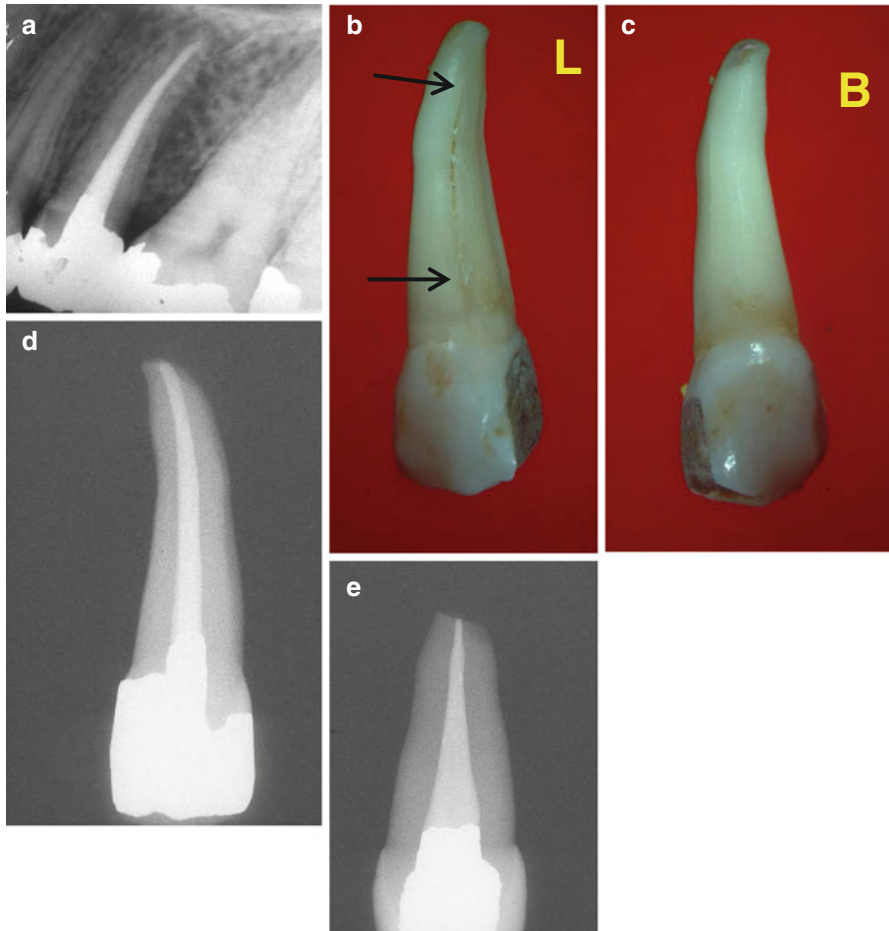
(a–e) Root canal therapy was performed on a maxillary second premolar as a result of chronic irreversible pulpitis. The root canal was obturated with laterally condensed gutta-percha (a). Shortly afterward and for several months, the patient complained of tenderness on biting. On clinical examination, the only sign noted was sensitivity to percussion. No probing, mobility, or bony radiolucency was noted even when the patient was examined 4 months post-op. The patient declined any further treatment, such as endodontic surgery. The tooth was extracted and cleaned. A VRF was found in the middle third of the palatal aspect of the root (*Arrows*) (b) but not in the buccal aspect (c). The well-obtained premolar can be seen in the bench periapical radiographs (d, e). This partial midroot palatal VRF could not be clinically diagnosed. This expresses the difficulties clinicians encounter in making accurate and timely VRF diagnosis (Courtesy Dr. Z. Elkes)
